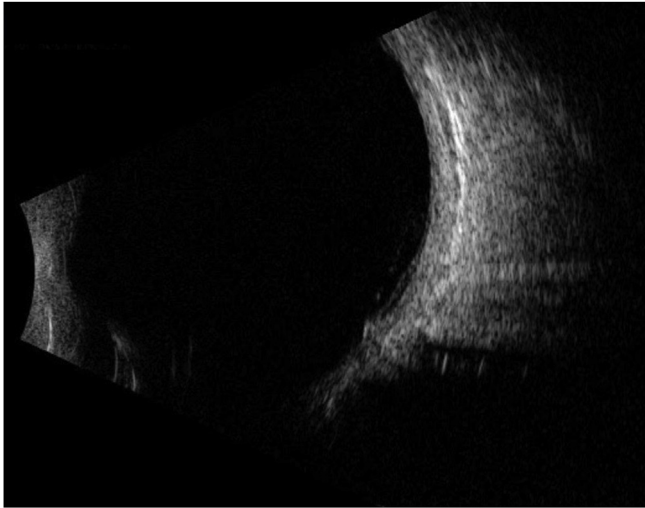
B scan ultrasonography at initial visit: increased echogenicity in the region of the infiltrate and hyperechoic material at optic nerve. At four months, the B scan was virtually the same suggesting stability of the lesion.
